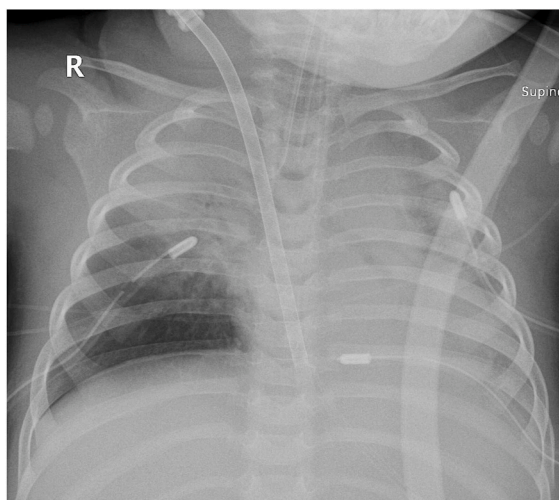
Day 4 chest X-ray after cannulation.
